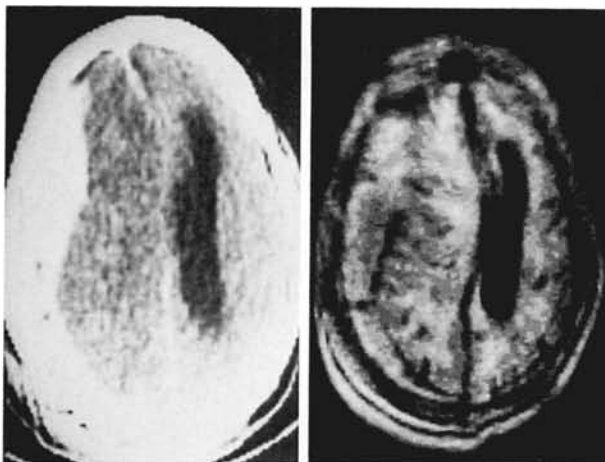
Acute subdural hematoma is hyperdense on CT scan (a) and faintly discernible in the inversion recovery 1,500(400)/30 image at 0.17 T (b).
